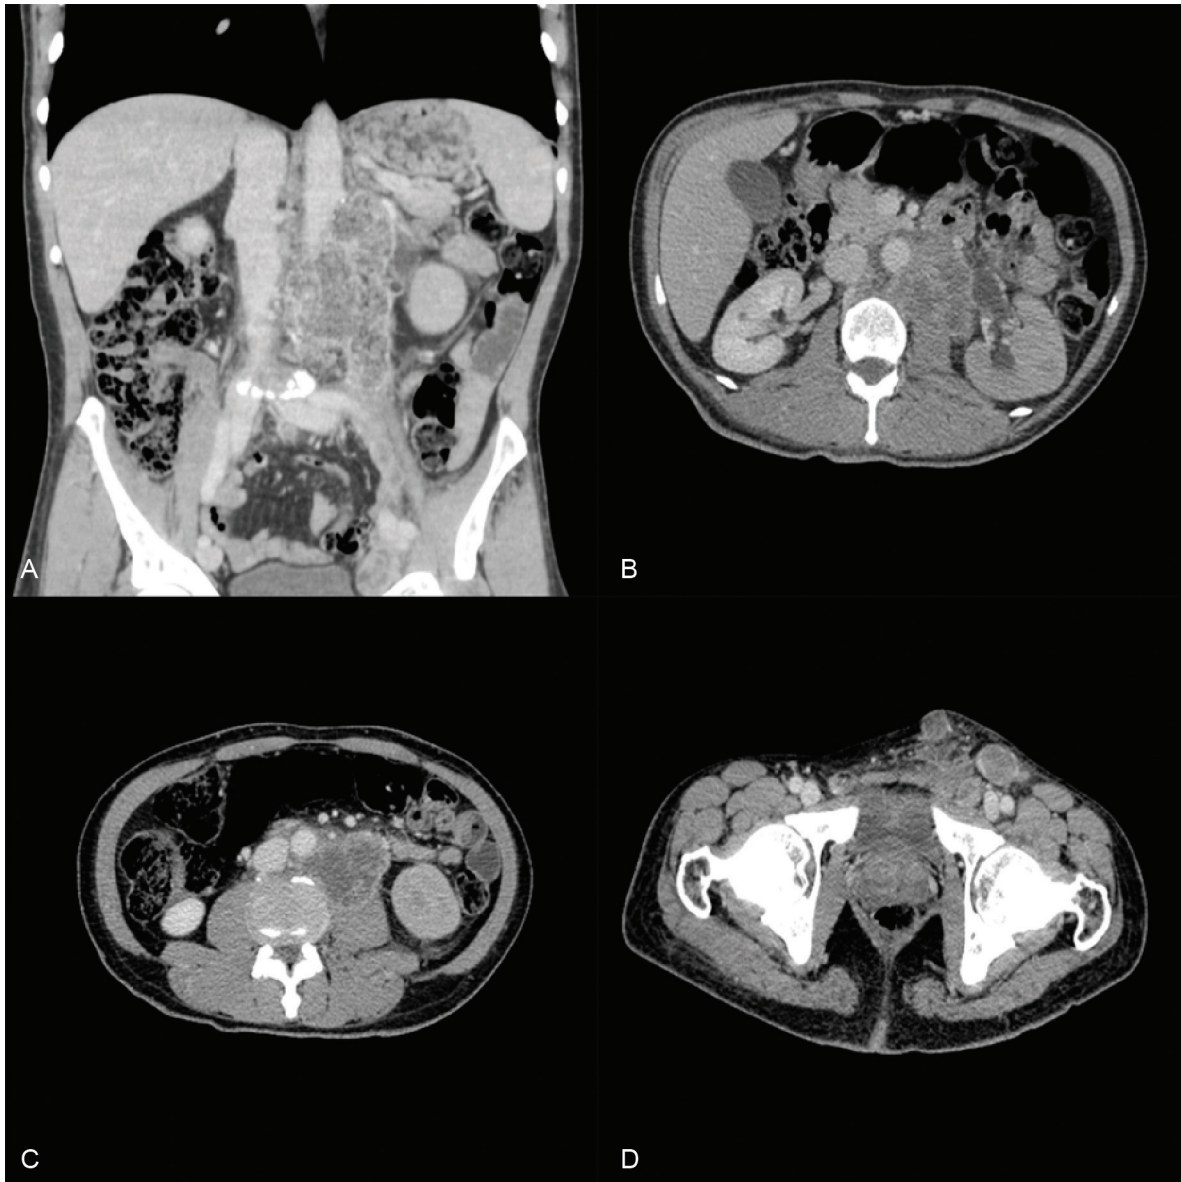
Abdominal CT. A – Coronal reformation showing a heterogeneous mass involving the aorta and left iliac artery; B – Axial plane showing periaortic lymph nodes, delayed concentration/excretion of the contrast, and slight hydronephrosis; C – Axial plane showing lymph nodes conglomerate with signs of central necrosis along the left iliac artery; D – axial plane – multiple bilateral enlarged inguinal lymph nodes.
